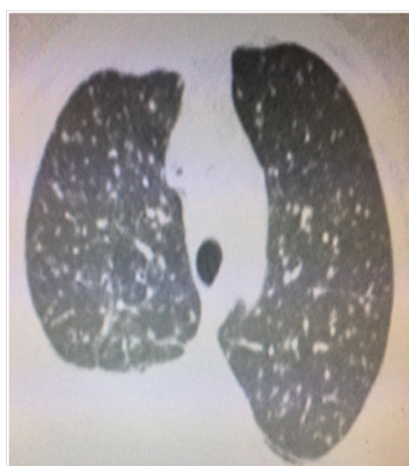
Axial computed tomography showing diffuse miliary nodules and right pleural effusion at the tracheal level.
